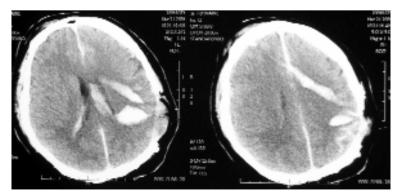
Intraoperative CT demonstrating the hemoragic densities along the arrow's pathway and the hematoma in the lateral ventricule.
